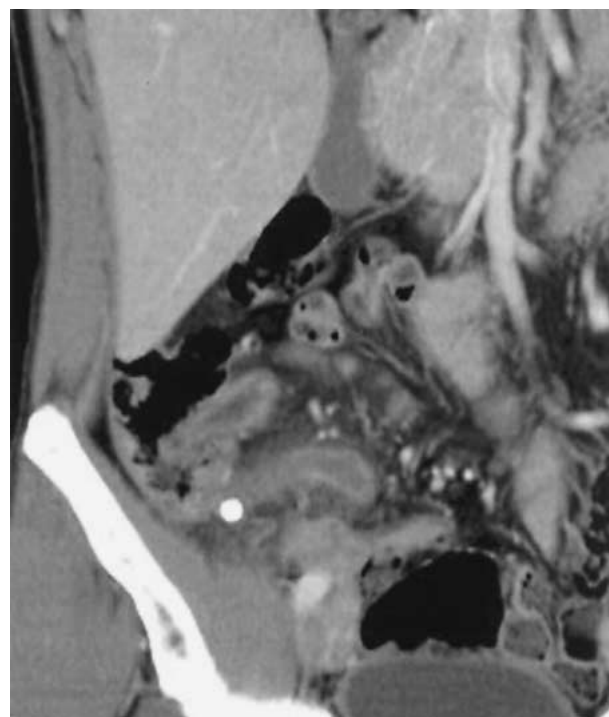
CT image of acute appendicitis without perforation. The dilated appendix is associated with an appendicolith and surrounding inflammatory change.
